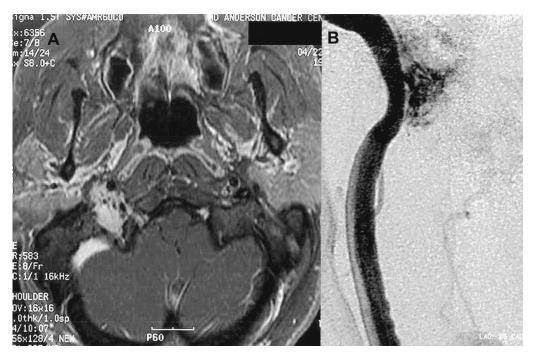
(A) Axial post-contrast T_1 -weighted MRI reveals signal voids within the contrast-enhancing tumor in the right jugular foramen. (B) Right lateral internal carotid angiogram confirms the hypervascular nature of this paraganglioma.
